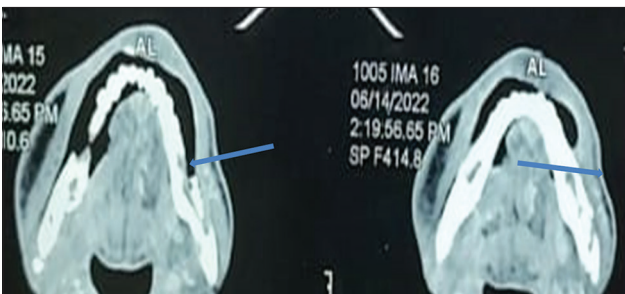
Axial view CT scan showing necrosed bone bilaterally and sequestration in the mandibular region
